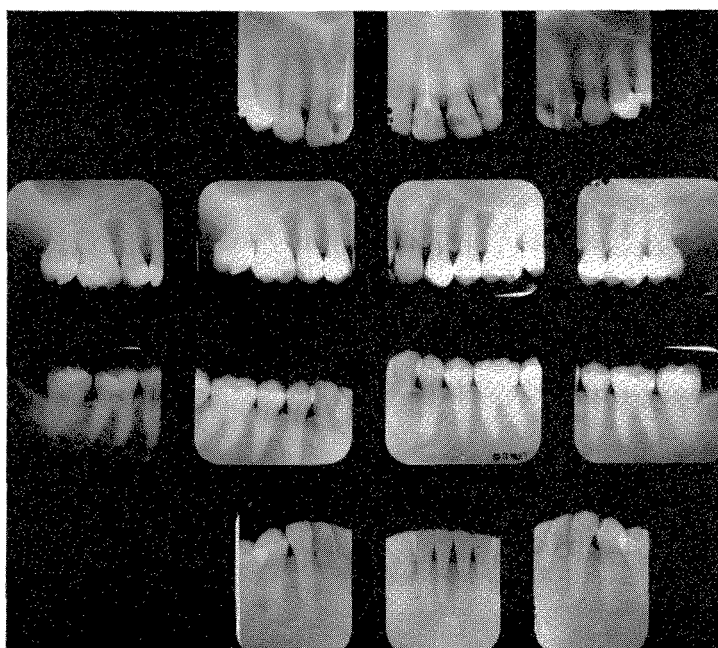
Roentgenograms taken in 1959 at the age of 46.
